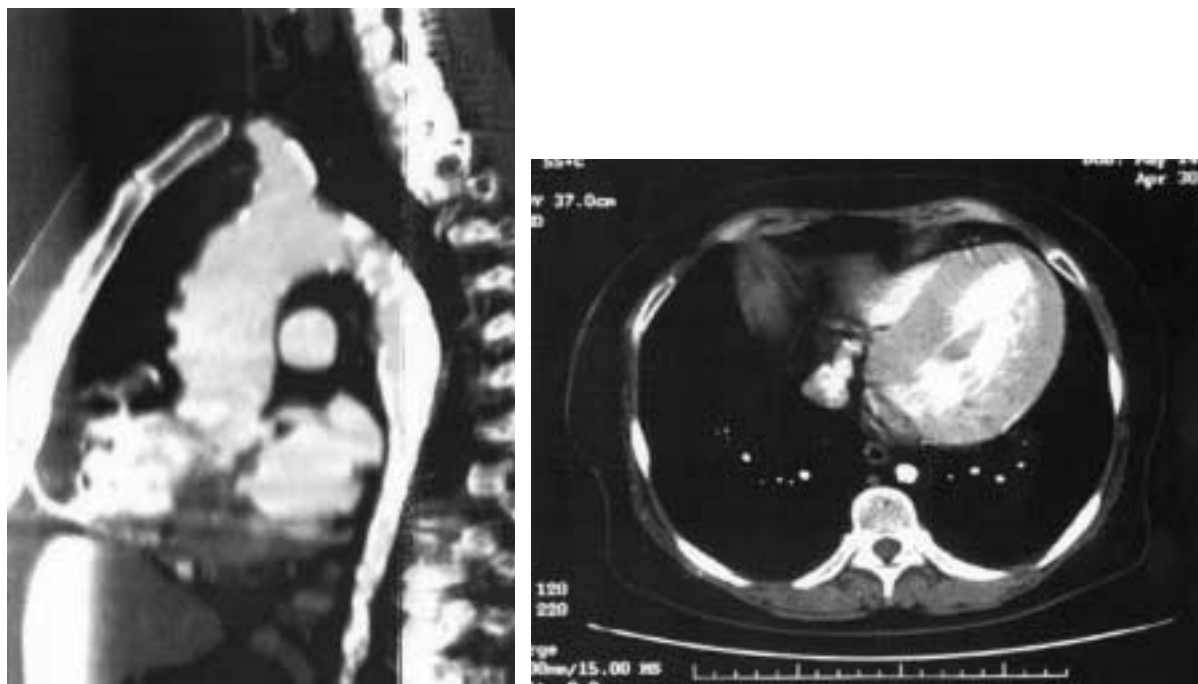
Preoperative CT findings in Patient 2. A: Left common carotid and subclavian arteries were occluded. B: Coarctate lesion in the descending aorta and left ventricular hypertrophy were revealed.
